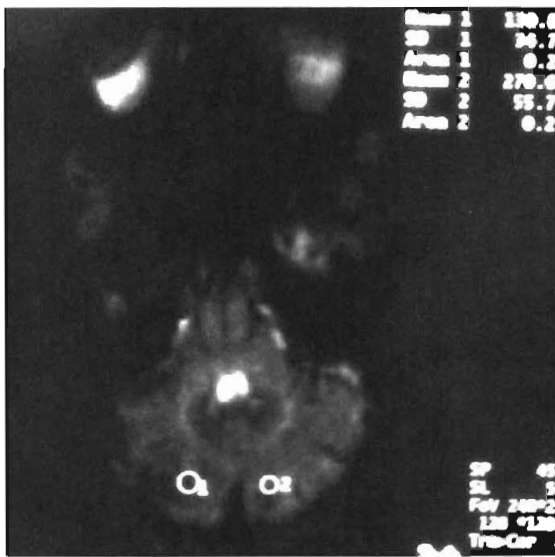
Perfusion deficit. MRI perfusion study shows hypoperfusion in the right posterior inferior cerebellar artery territory. The normal left side measured 270.6, and the abnormal right side measured 130.8.
